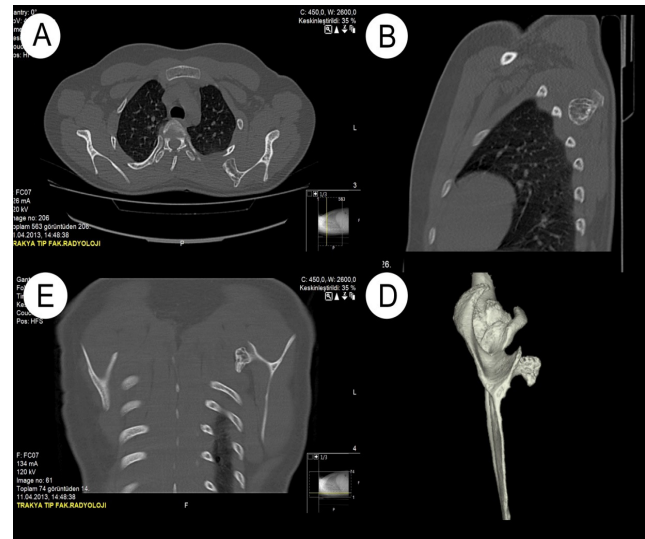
A) sagittal plane B) axial plane C) coronal plane D) three dimensional view of the osteochondroma originated from ventral side of superior angle of the left scapula on the computed tomography for further examination.
